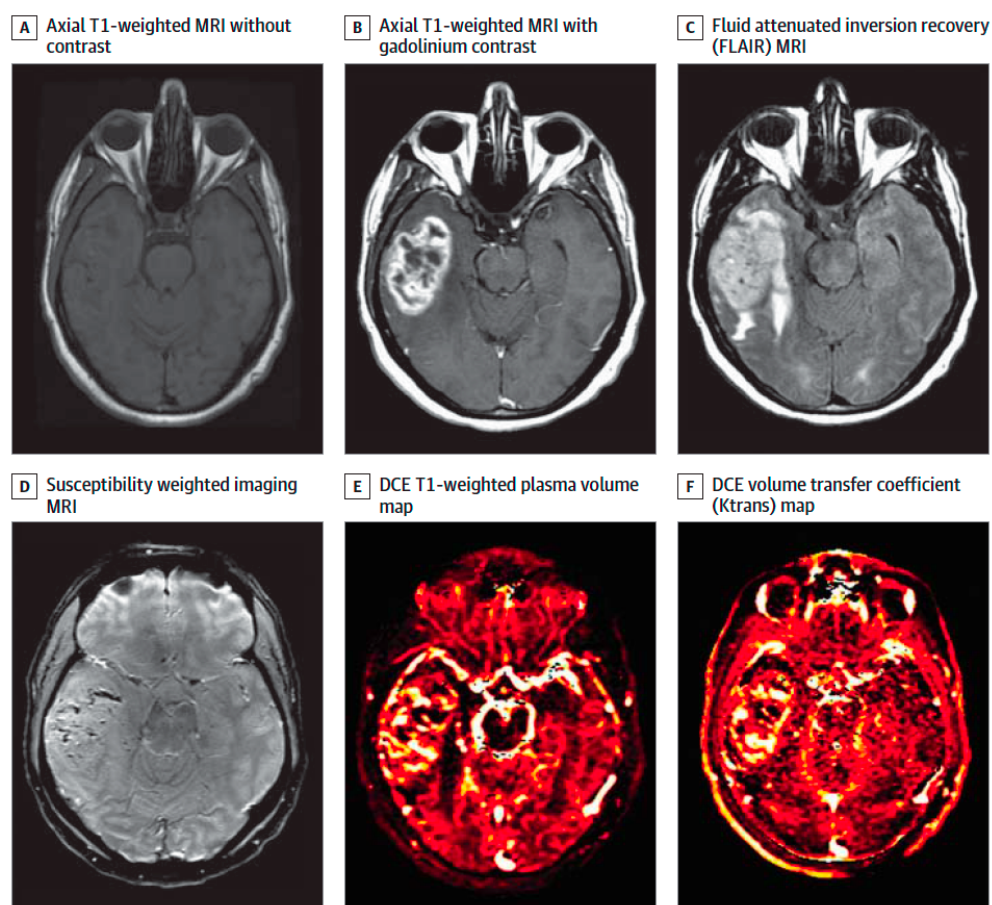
Neuroimaging studies of glioblastoma multiforme. Typical glioblastoma features on magnetic resonance imaging (MRI) studies used in the initial evaluation of a suspected brain tumor. Special techniques (B-C) must be used to see the tumor at all (A), and the extent of infiltration of tumor tissue into the healthy brain (from Omuro & DeAngelis 2013).
